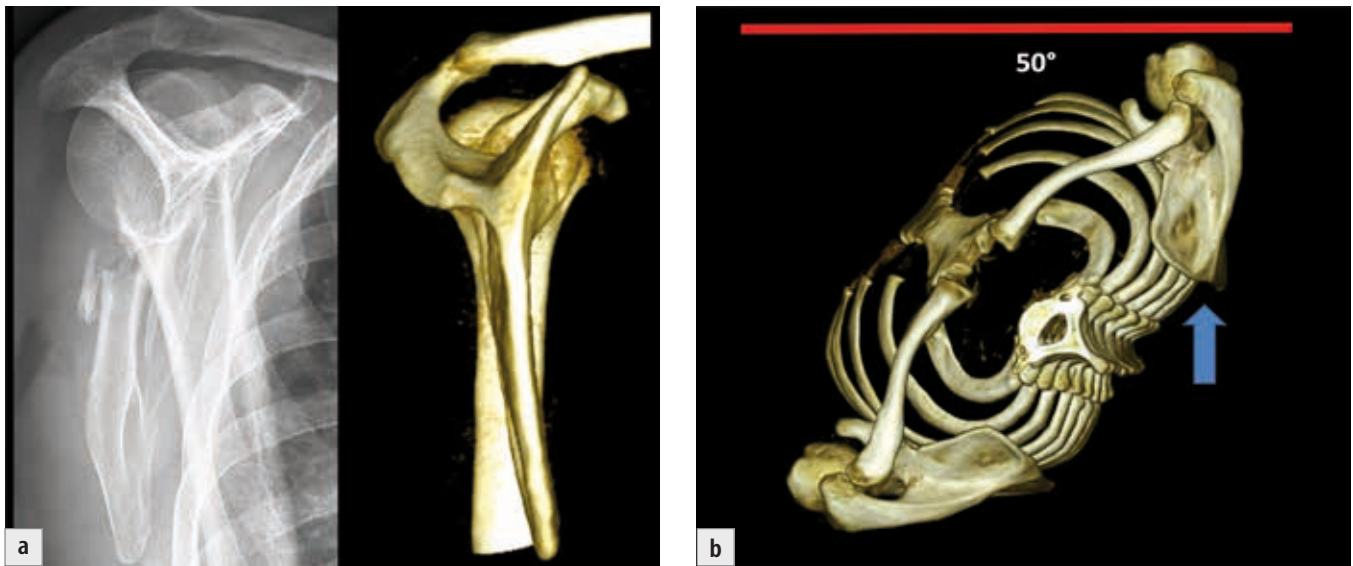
Lateral view of the scapula (Neer II projection): a) radiograph and CT reconstruction; b) position of the scapula and the X-ray cassette.
